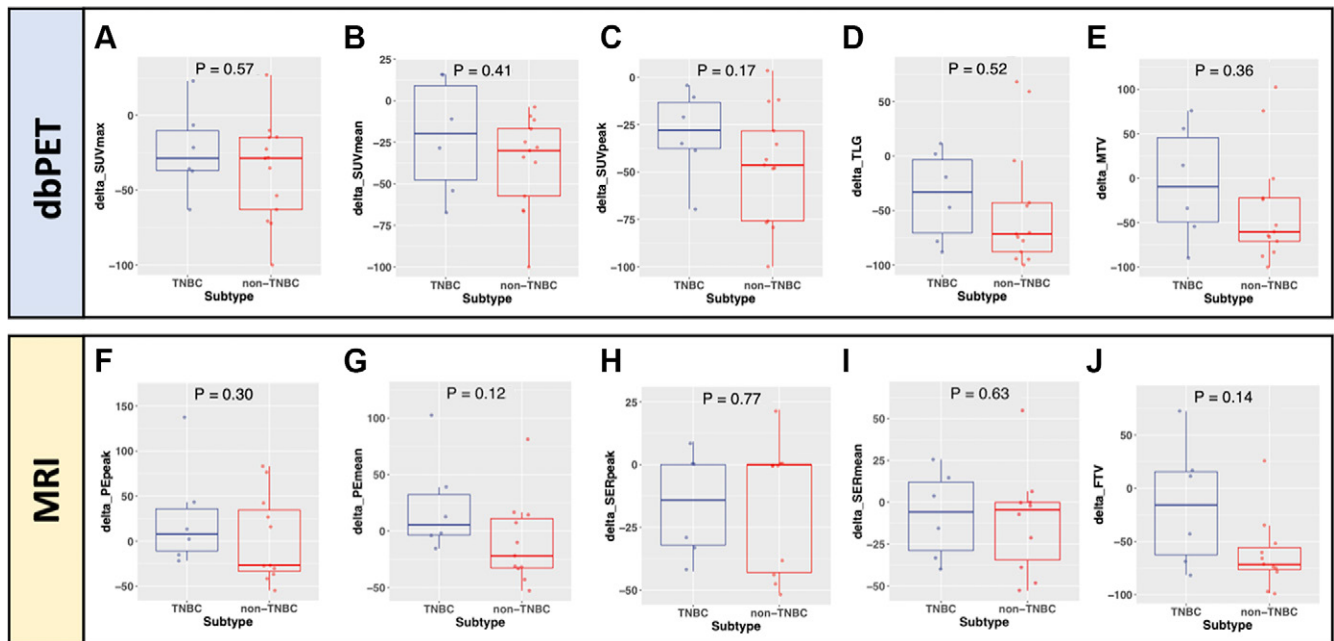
Box-and-whisker plots show comparison of the change between T0 and T1 (delta) in parameters of fluorine 18 fluorodeoxyglucose uptake at dedicated breast PET (dbPET) and MRI parameters in participants with triple-negative breast cancer (TNBC) and non-TNBC. (A–E) dbPET parameters: (A) maximum standardized uptake value (SUV), (B) mean SUV, (C) peak SUV, (D) total lesion glycolysis (TLG), and (E) metabolic tumor volume (MTV). (F–J) MRI parameters: (F) peak percent enhancement (PE), (G) mean PE, (H) mean signal enhancement ratio (SER), (I) peak SER, and (J) functional tumor volume (FTV). The boundaries of the boxes indicate the lower and upper quartiles, the lines within the boxes indicate the medians, and the whiskers indicate the range (not including outliers).
